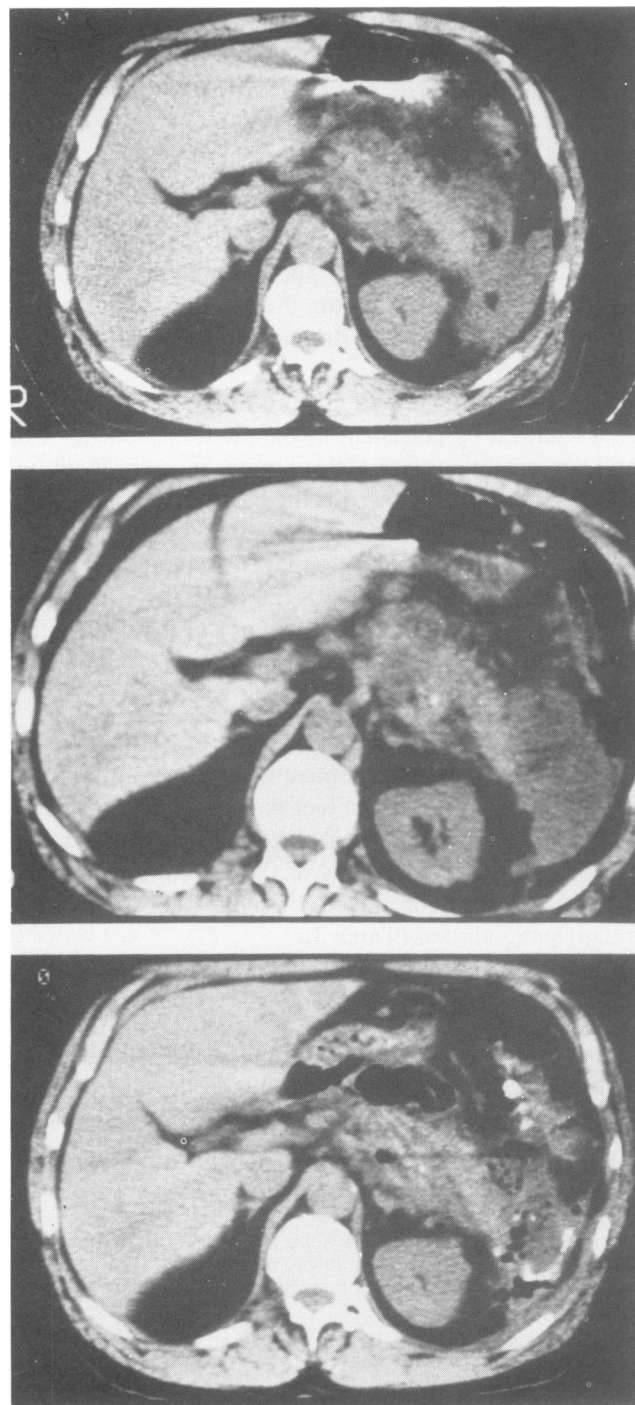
Serial CT scan of the pancreas at 10, 20, and 30 days after onset of acute pancreatitis. Progressive changes are evident: phlegmonous swelling and edema (top); irregular lucent areas consistent with liquefaction necrosis, along with extension to the left perirenal space (middle); gas bubbles within a pancreatic abscess (bottom).
